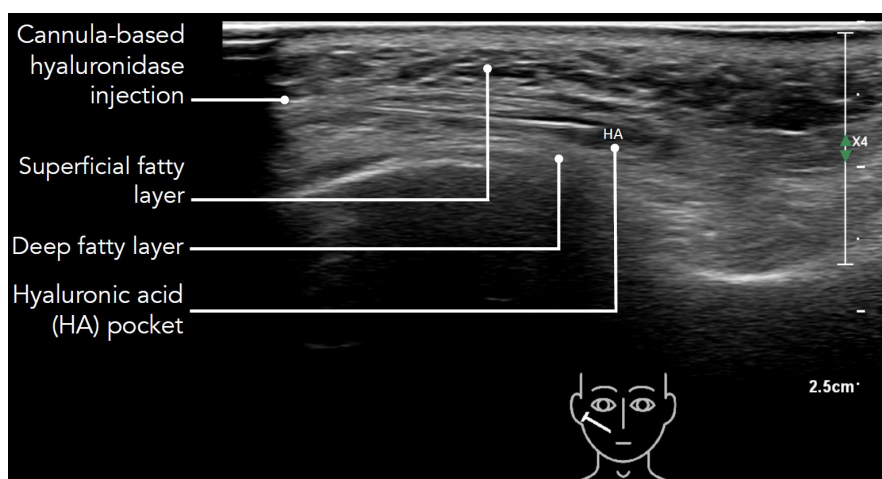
Ultrasound image showing the oblique scan of the midface as indicated in the overview. The hyaluronic acid-based filler material is visible (HA) inside the fibrous layer closely related to the zygomaticus major muscle between the superficial and the deep fatty layers. The cannula is visible during the application of hyaluronidase.
